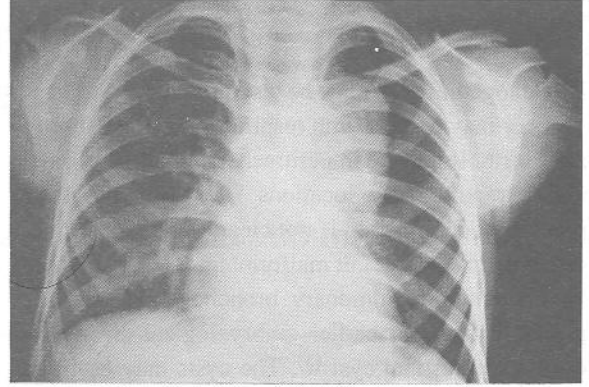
Posteroanterior chest x-ray in case 4. Note the mass image of left peritracheal bronchogenic cyst.
